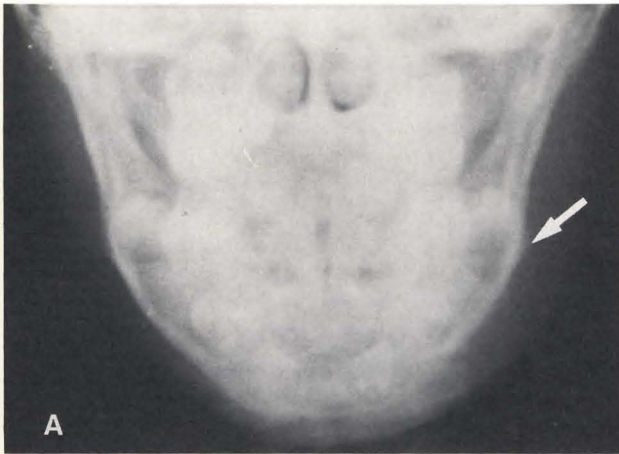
P-A cephalometric radiograph showing left facial asymmetry and reactive bone.
